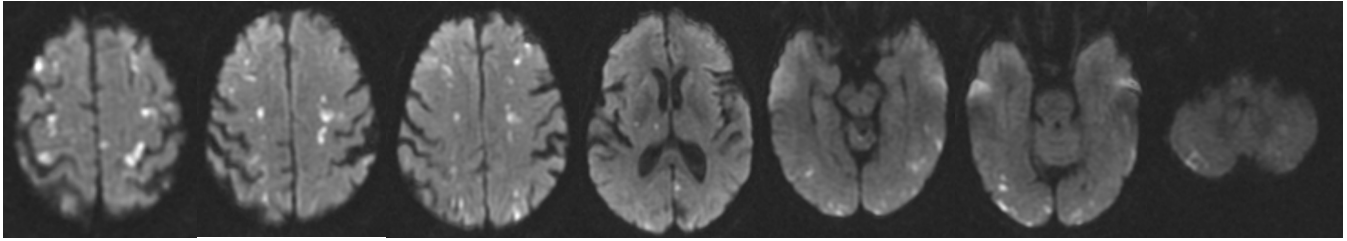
MRI DWI sequences showing acute punctate infarcts in watershed distribution.
